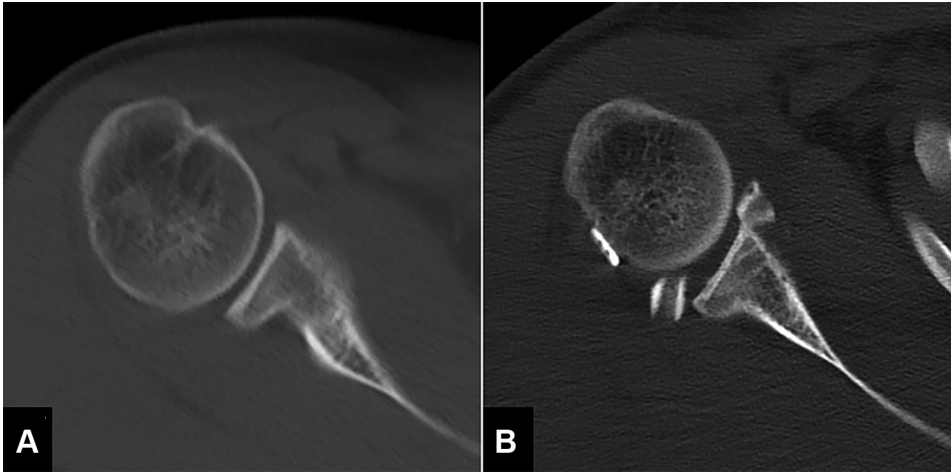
(A) Pre- and (B) post-operative transverse view computed tomography images of right shoulder.
